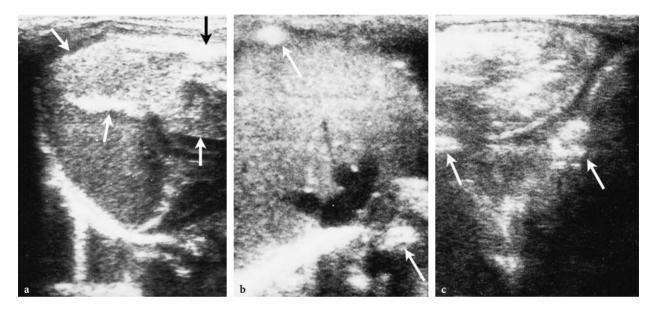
Meconium peritonitis in a neonate with cystic fibrosis. Sonography demonstrates intraabdominal calcifications over the liver surface (a), around the spleen (b), and around the bowel loops (c) (*arrows*). Note the hyperechogenic inspissated meconium into the bowel loops
